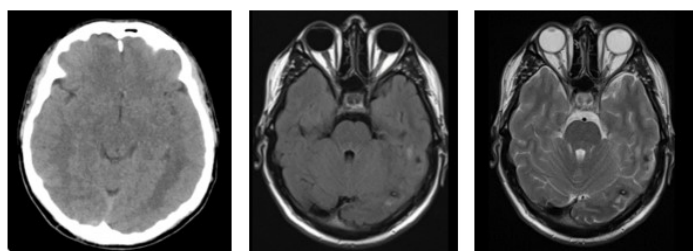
Post-treatment brain CT and MRI images
